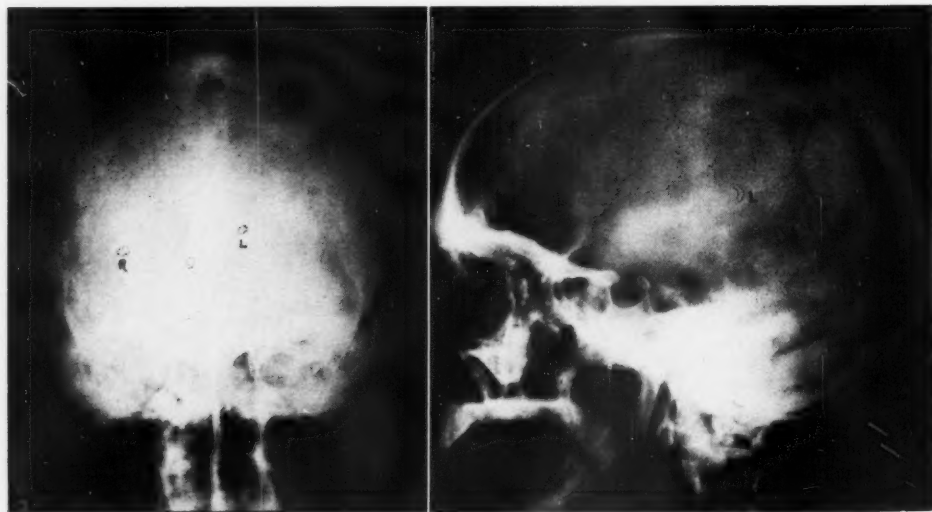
Case 3. 105,898. C. K. Left posterior cerebral tumor verified (glioblastoma multiforme) in a male subject aged 61 years. Displacement of left ventricular choroid plexus forward, medially, and upward. Displacement of pineal gland to the right of the midline. Verification of a massive tumor by left temporo-parietal craniotomy, localizing the tumor in temporal, parietal, and occipital lobes. Subsequent treatment by roentgen therapy.
